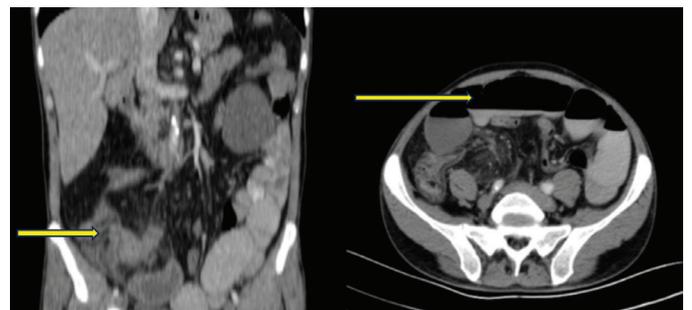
Stricture and mechanical bowel obstruction due to Crohn's disease. Computed tomography image
